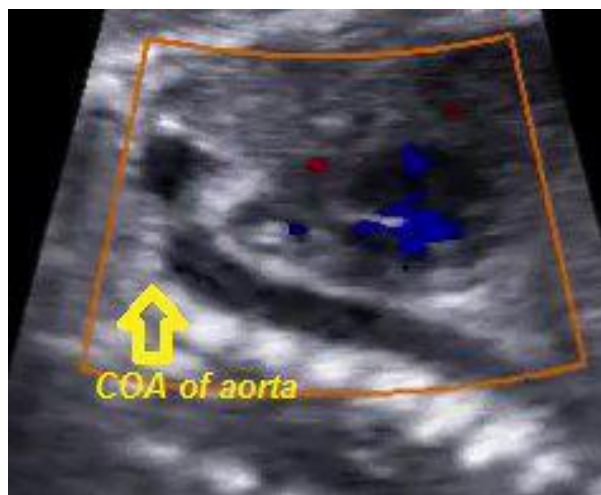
Aortic arch view in fetal echocardiography showed significant stenosis in proximal part of descending aorta (DAO).
